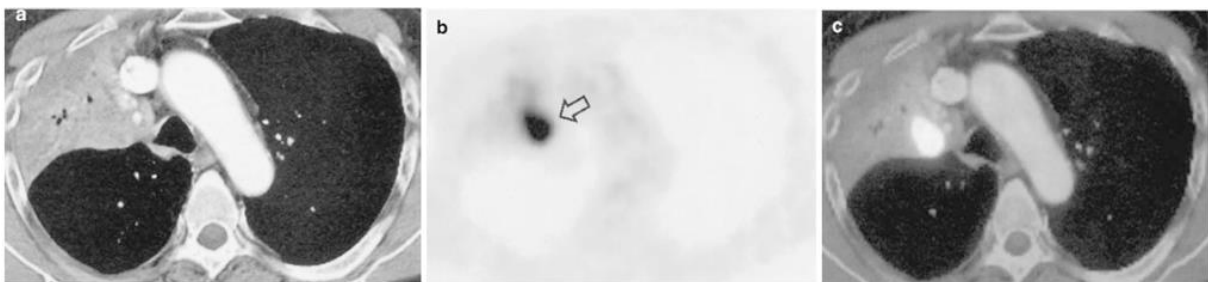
Transverse (a) CT, (b) PET, and (c) PET/CT fused images of a thorax with non-small cell lung carcinoma ($[^{18}\text{F}]\text{FDG}$).⁶
